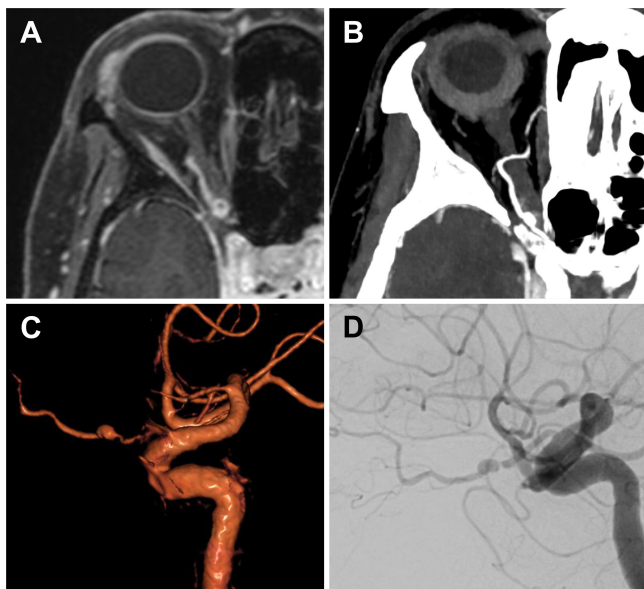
A: Axial contrast-enhanced MR image showing a nodular lesion at the right orbital apex. B: Axial CT angiogram of the head showing fusiform dilation of the right OphA at the orbital apex. C: Three-dimensional reconstruction of CT angiogram of the head showing a fusiform aneurysm in the OphA. D: Lateral view of digital subtraction angiogram showing a pearl and string sign in the OphA.
